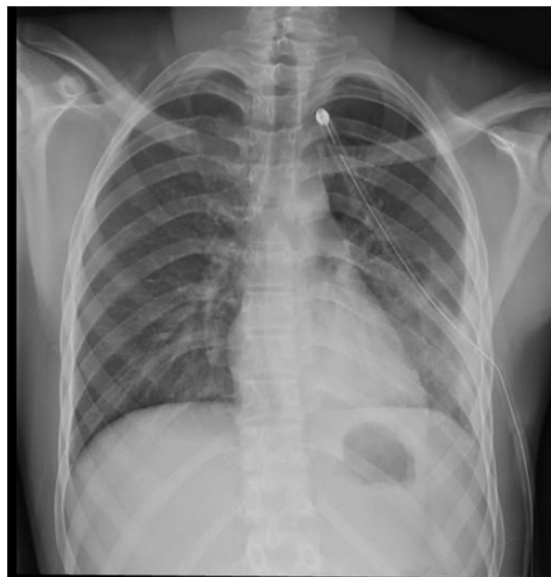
Post-drainage chest X-ray showing the return of the lung to the wall
